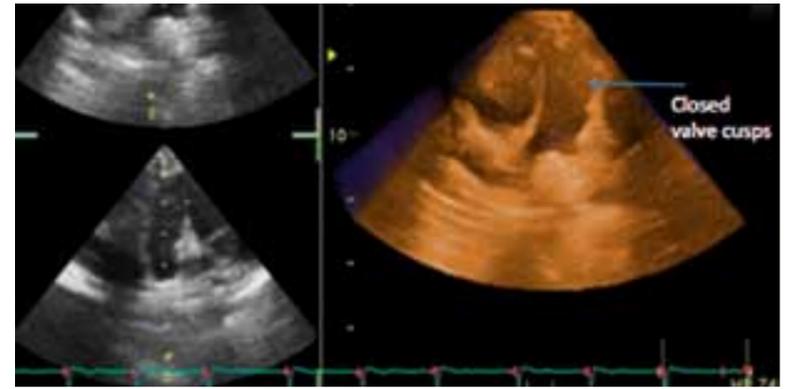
Anatomy of reconstructed pulmonary valve at five v year. (Image produced by 3D echocardiography).
